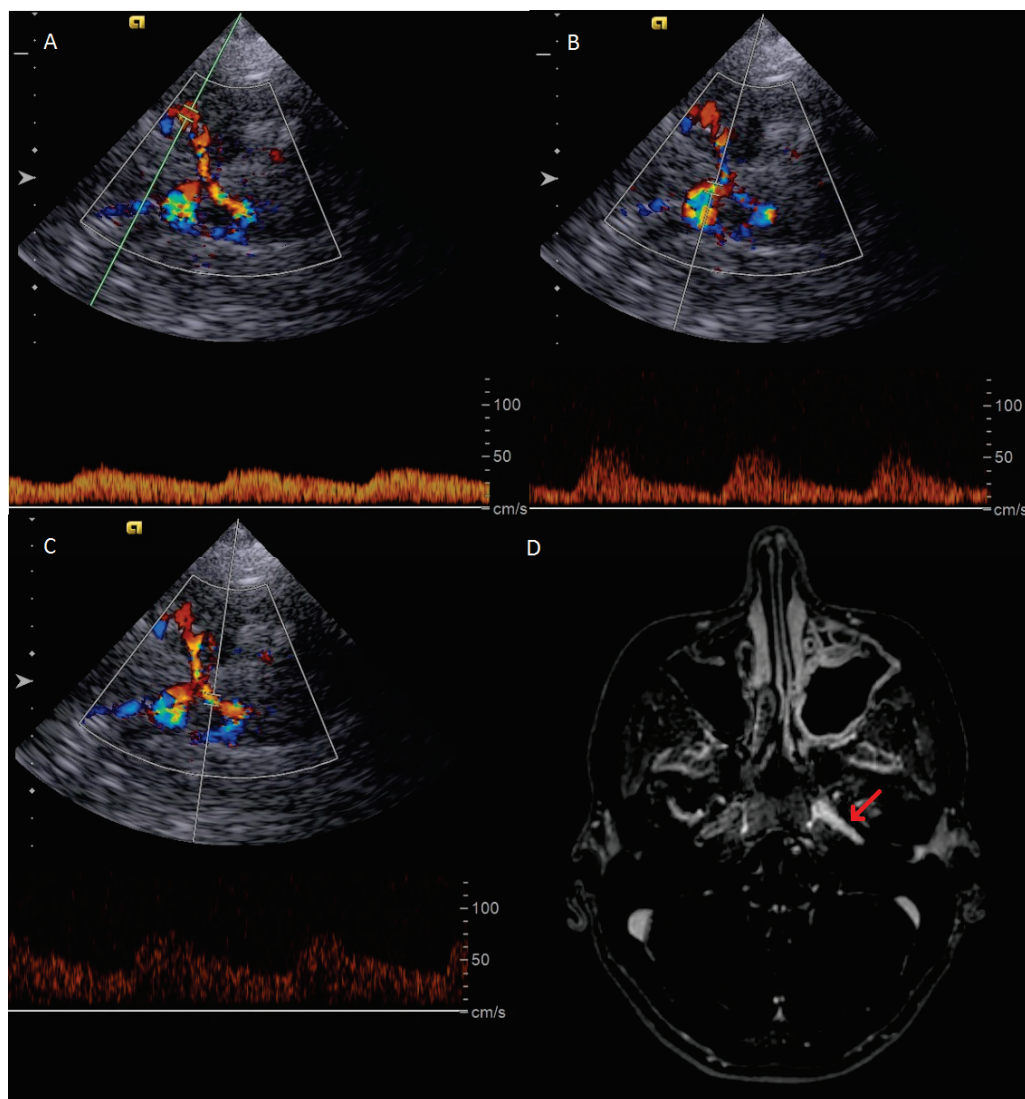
Exemplary case of a patient with TAK and images of a follow-up examination 5 years after the first diagnosis showing signs of high-grade stenosis of the left distal ICA. (A) Transcranial duplex sonography showing reduced pulsatility of the left distal MCA. (B) Retrograde perfused left ACA. (C) Cross-flow circulation from the left PCA to the left MCA through the posterior communicating artery (D) MRI scan (subtraction T1-weighted 3D TRA sequence) confirming high-grade stenosis and vascular inflammation of the left distal ICA (red arrow).
